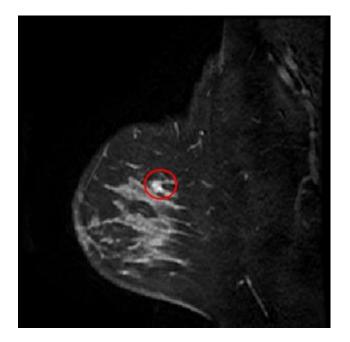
Original MR image with lesion area highlighted after visual inspection and reference to radiology report. Image acquired at 2 minutes post contrast using a high resolution 3D T_1 weighted sequence. Patient is a 40 years old female with a benign lesion (fibrodenoma and corresponding fibrocystic disease) in the left breast
